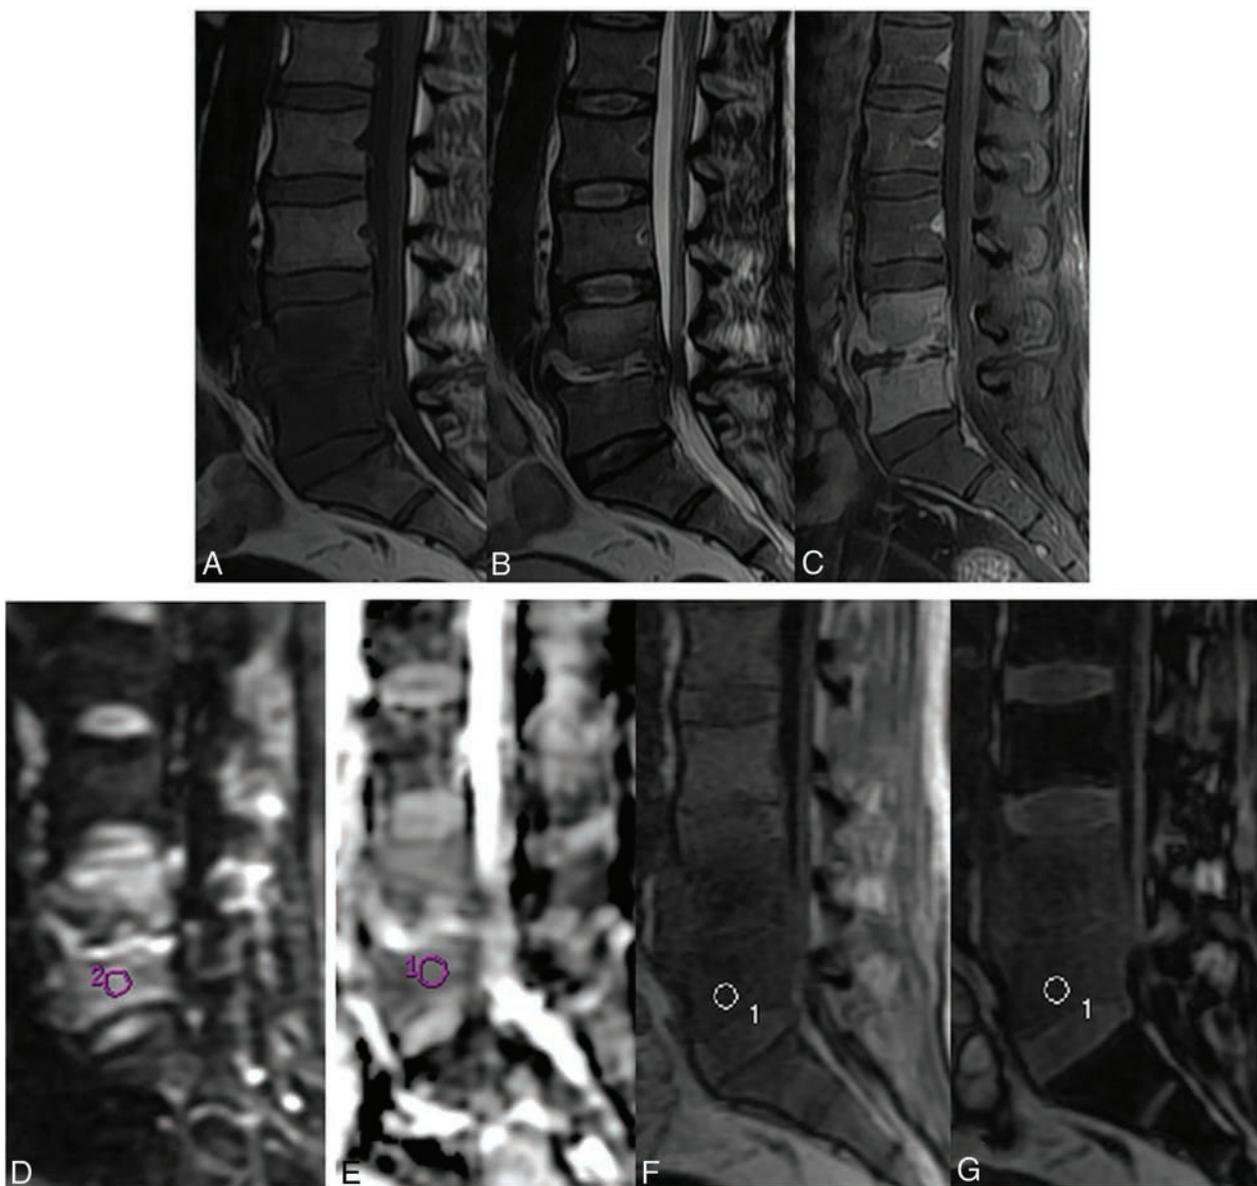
A 35-year-old man with biopsy-proved vertebral tuberculosis shows diffusely hypointense signal in the L4 and L5 vertebrae on sagittal T1WI (A) and hyperintense signal on sagittal T2WI (B). The intervening disc space has a small amount of prevertebral and epidural soft tissue. Heterogeneous enhancement of both the involved vertebrae, intervertebral disc space, and prevertebral and epidural soft tissue is noted on the contrast study (C). The lesion is mildly hyperintense on DWI (D). ADC measured from the L5 vertebral body is $1.2 \times 10^{-3} \text{ mm}^2/\text{s}$ (E). Sagittal in-phase (F) and opposed-phase (G) images with the ROI cursor drawn in the lesion are shown. The measured SIR is 0.88.
